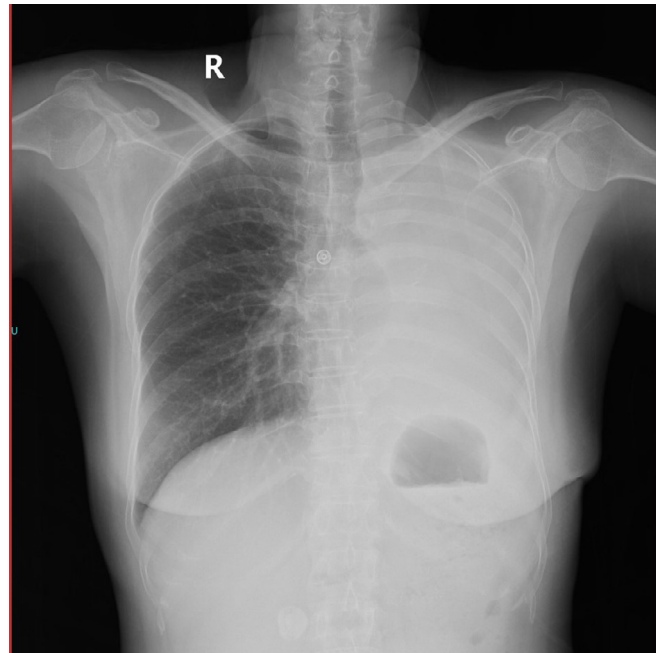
X-ray evaluation 2 months post thoracotomy.
